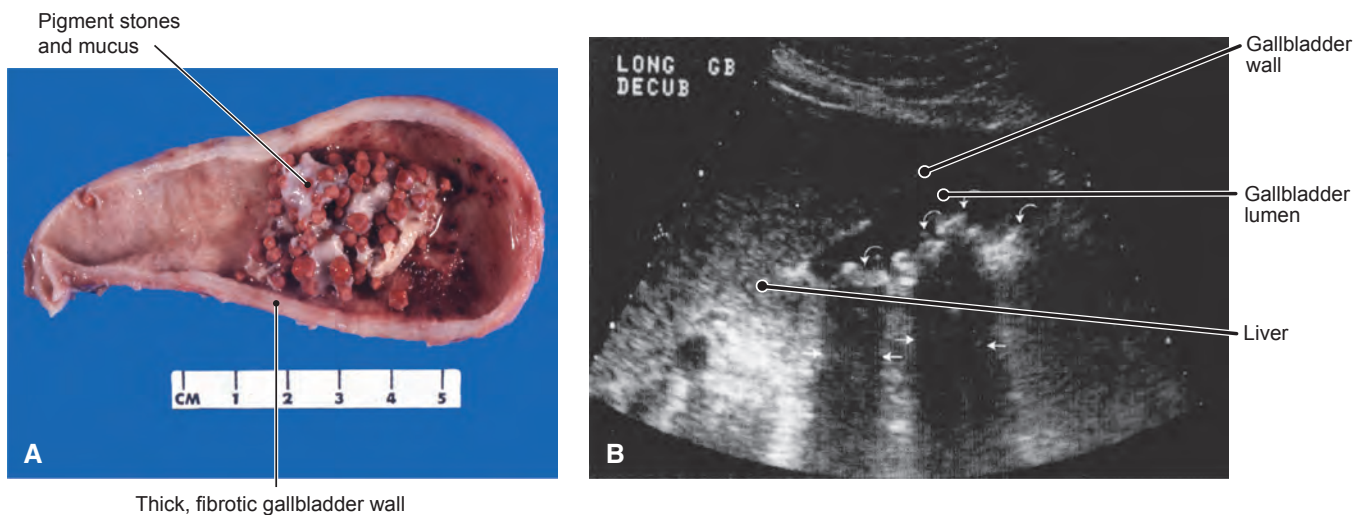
Cholelithiasis (gallstones). A. Formation of gallstones (cholelithiasis) causes gallbladder inflammation (cholecystitis) and bile obstruction. Numerous gallstones and a thickened gallbladder wall caused by chronic inflammation are evident in this figure. B. Sonogram shows dense gallstones (*curved arrows*). Shadows appear (between the *straight arrows*) because the sound waves cannot penetrate the stones (calculi).
